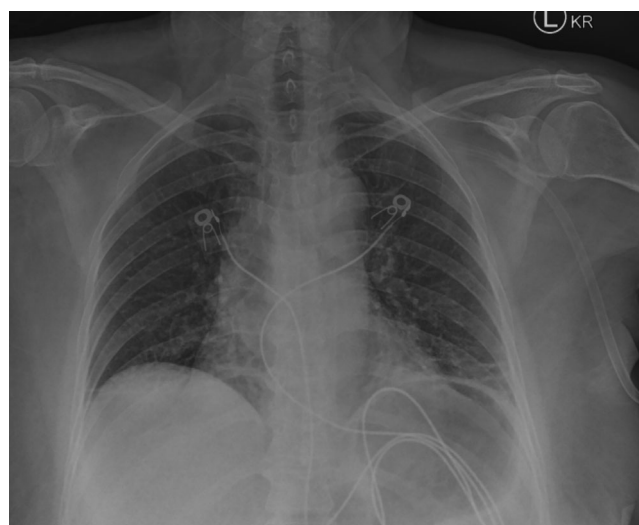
Plain radiograph of the chest (anterior posterior view) showed widening of the mediastinum and an indistinct aortic knob.
